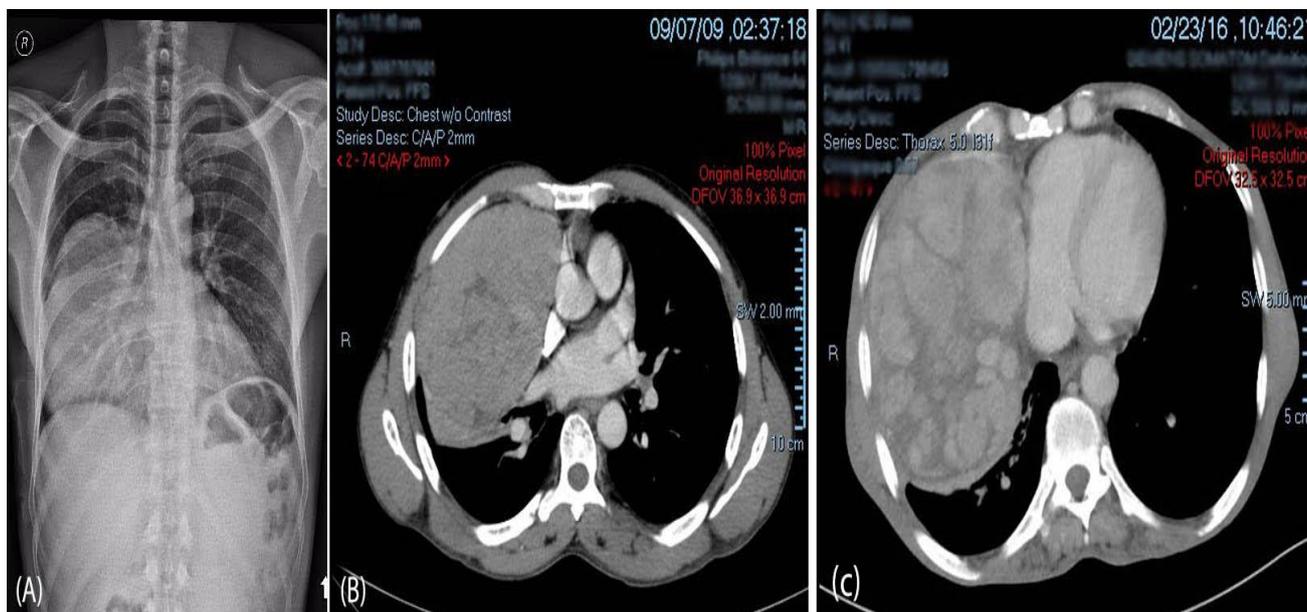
(A) Chest x-ray showed right lung mass. (B) CT chest showing right lung soft tissue mass. (C) CT chest showing large right soft tissue mass, lobulated in nature.
